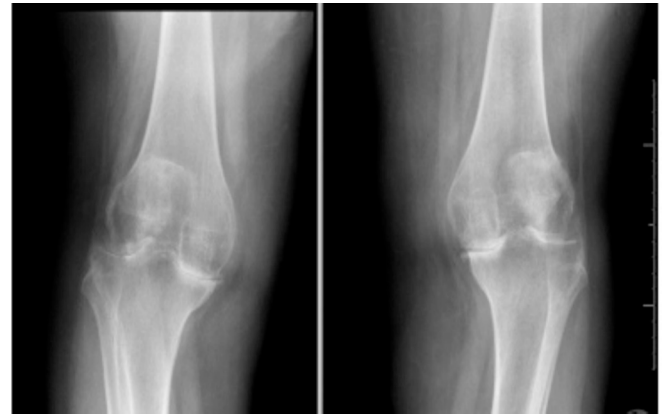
Knee Osteoarthritis X-Ray.
